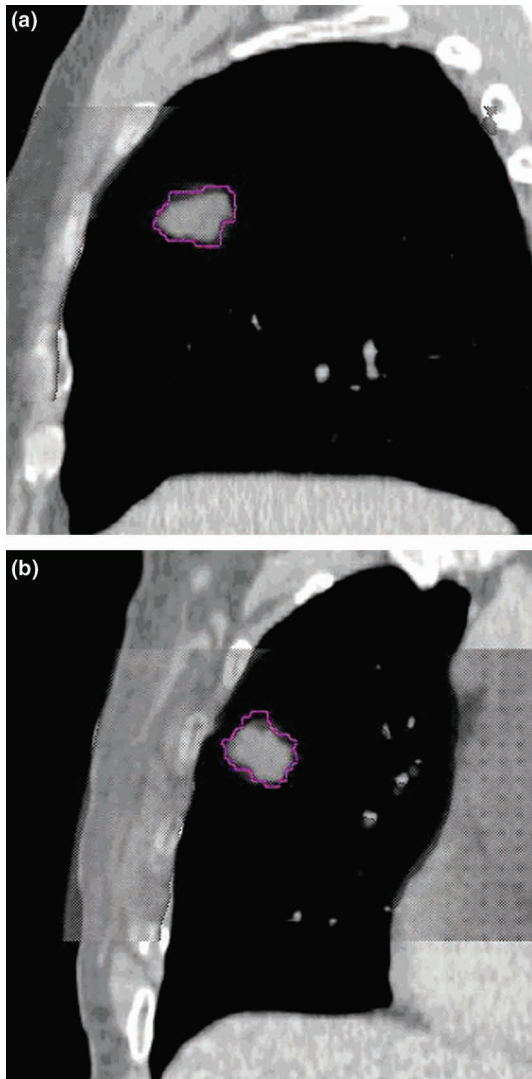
The matched planning CT and CBCT images used for target localization for one fraction. The GTV from planning is outlined. The CBCT images were reconstructed from the full projection set for the patient in Figure 1 in (a) sagittal and (b) coronal orientations.
